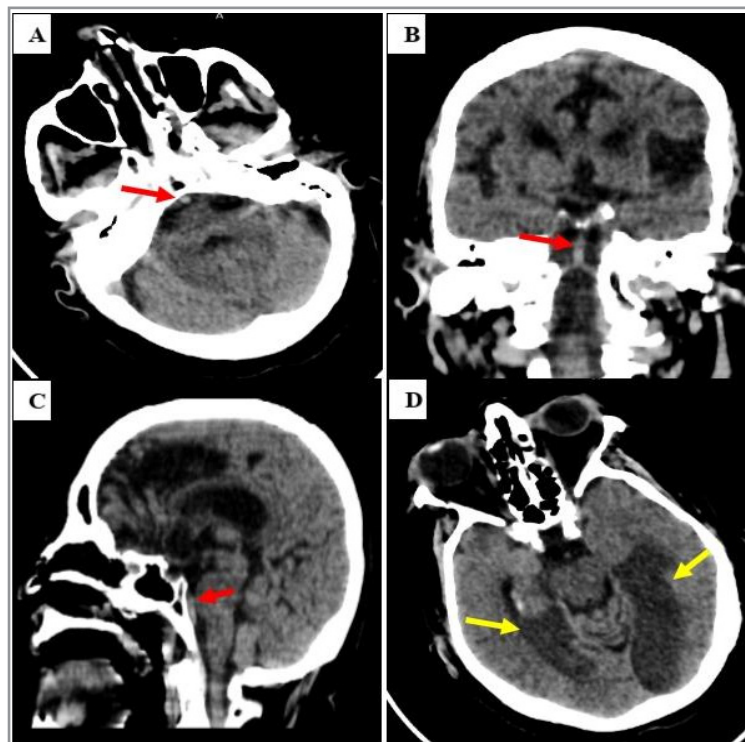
Cerebral CT scan without contrast injection: A (Axial section), B (Coronal section), and C (Sagittal section): Spontaneously hyperdense appearance of the rostral portion of the basilar artery (Red arrow). D: Axial section showing bilateral cortico-subcortical temporo-occipital hypodense areas (Yellow arrow).
